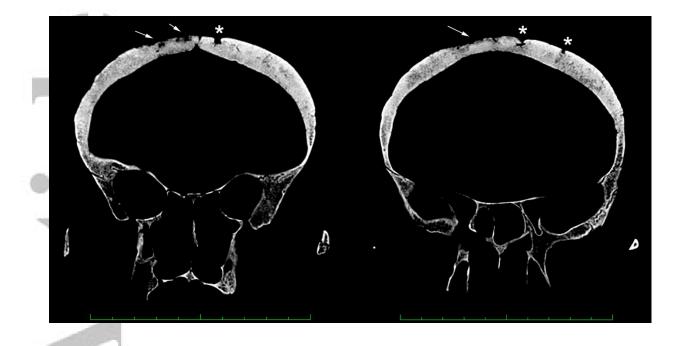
Coronal CT sections of cranium CG19O-706, note the osteolytic destruction of the external table (arrows) and the nodular formation around some osteolytic lesions (asterisks)
